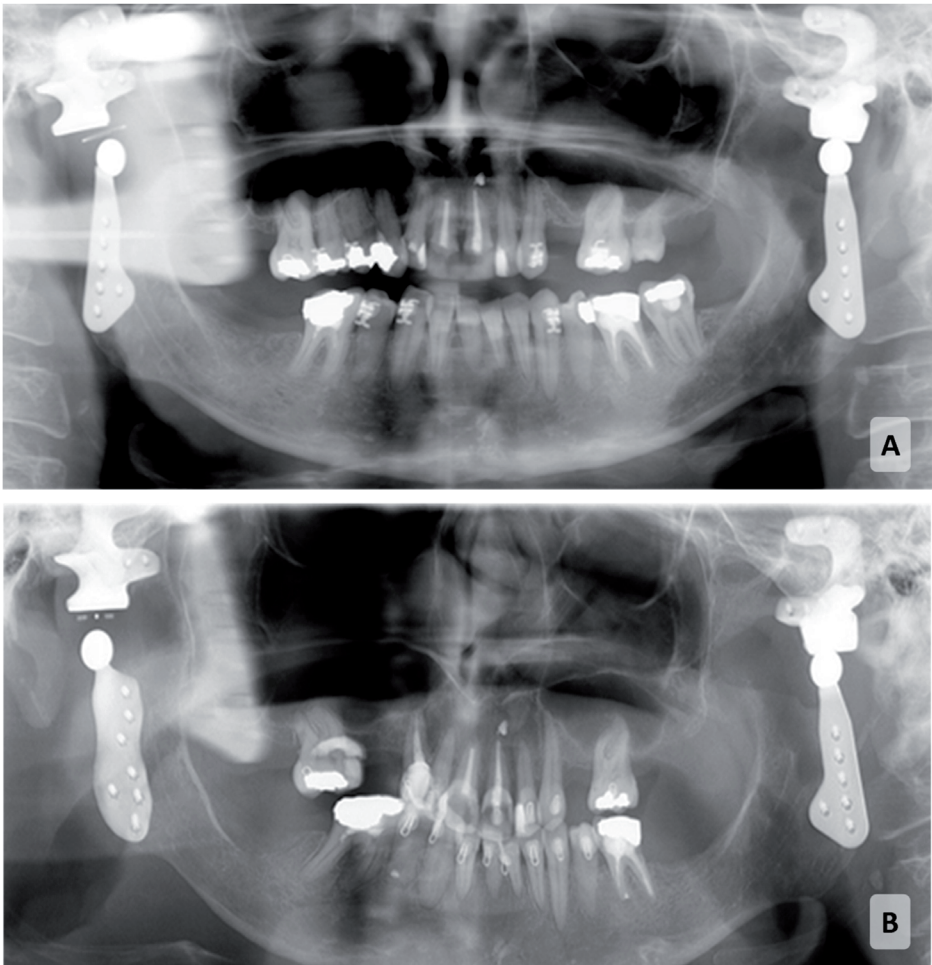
Panoramic radiographs obtained (A) pre-revision and (B) post-revision of the right-side TMJ-TJR in patient 1. Due to prior suboptimal positioning of the mandibular component, the stock G-TMJ-TJR was not satisfactory. This indicates the difficulty that can present with stock prostheses and/or without the use of surgical guides.
